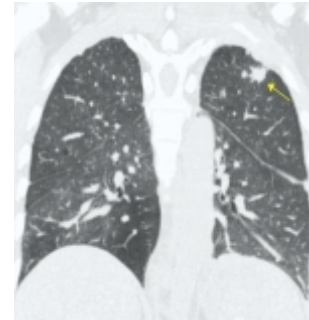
CT Thorax showing patchy consolidation, centrilobular nodules and tree in bud pattern suggestive of an infective etiology
